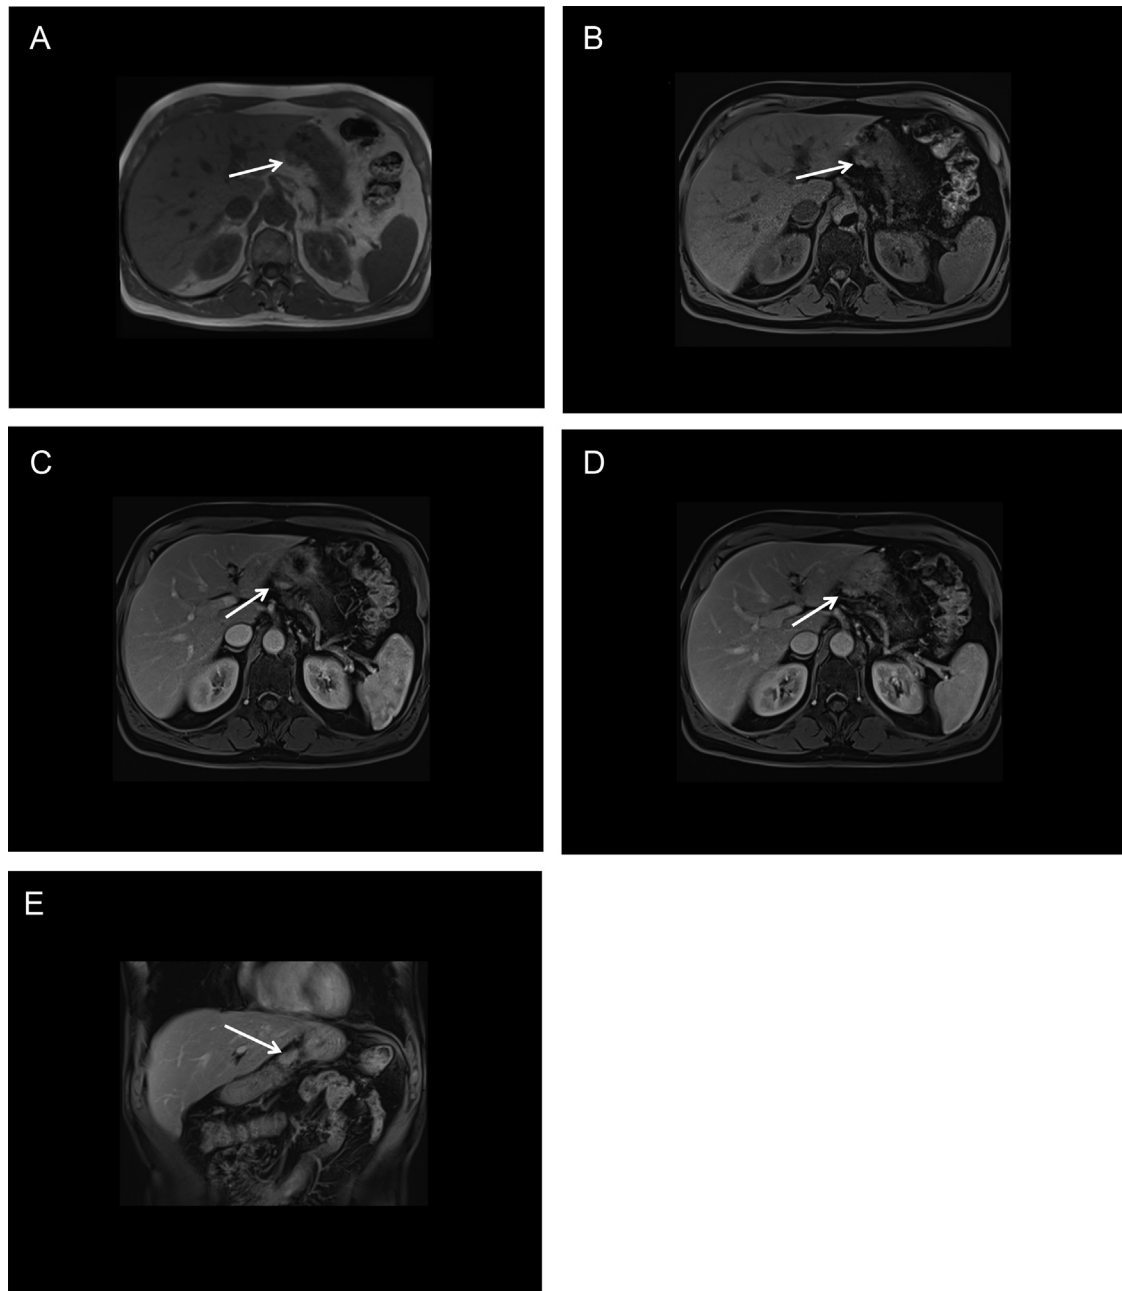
Gastric ectopic pancreas on magnetic resonance imaging (patient A). Magnetic resonance images: Axial T1-weighted in-phase (A), fat-suppressed T1-weighted precontrast (B), fat-suppressed T1-weighted postcontrast (arterial, C and venous, D) sequences and fat-suppressed T1-weighted postcontrast in the coronal plane (E) showing a subepithelial lesion (arrow) with precontrast high T1 signal intensity and a hypervascular enhancement.
